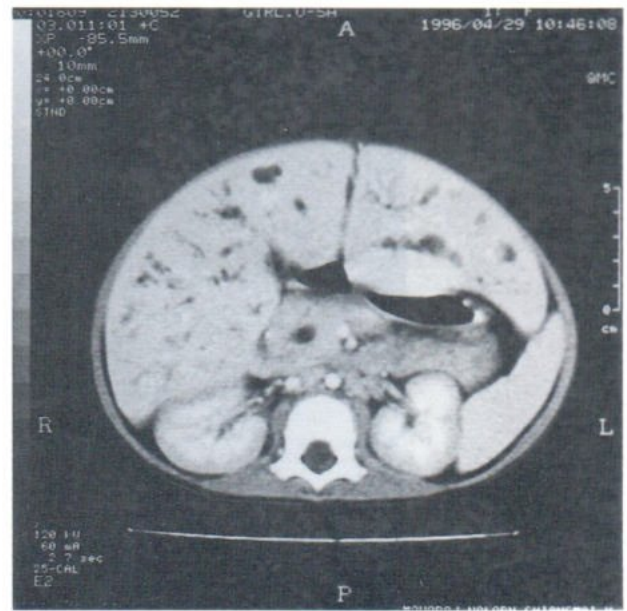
Contrast CT scan shows striation of the renal medullas in both kidneys, hepatomegaly, saccular dilatation of intrahepatic ducts, and mild dilatation of the common bile duct.
